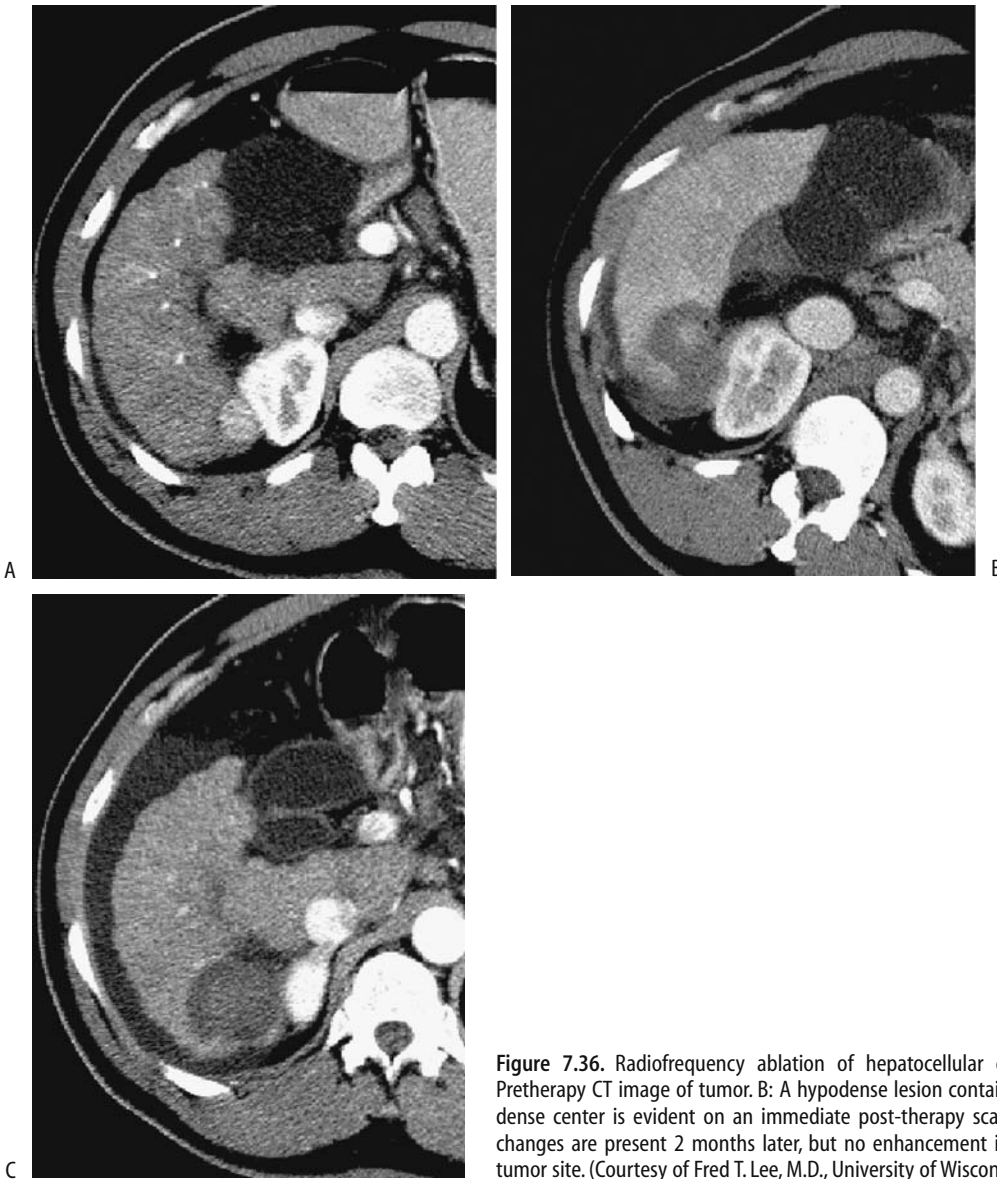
Radiofrequency ablation of hepatocellular carcinoma. A: Pretherapy CT image of tumor. B: A hypodense lesion containing a hyperdense center is evident on an immediate post-therapy scan. C: Residual changes are present 2 months later, but no enhancement is seen within tumor site. (Courtesy of Fred T. Lee, M.D., University of Wisconsin.)
